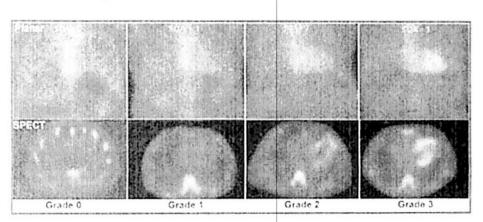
Grading *Tc-PYP Uptake on Planar and SPECT Images
